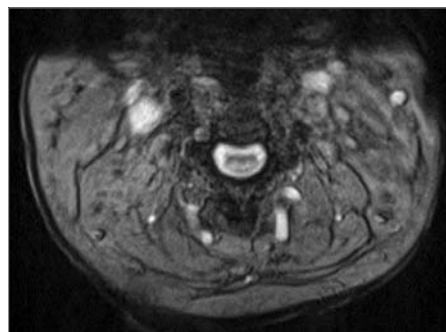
Magnetic resonance image (cross sectional view) of cervical spine at level of documented myelomalacia. Signal intensity changes (whitening of spinal cord) demonstrates presence of myelomalacia.
